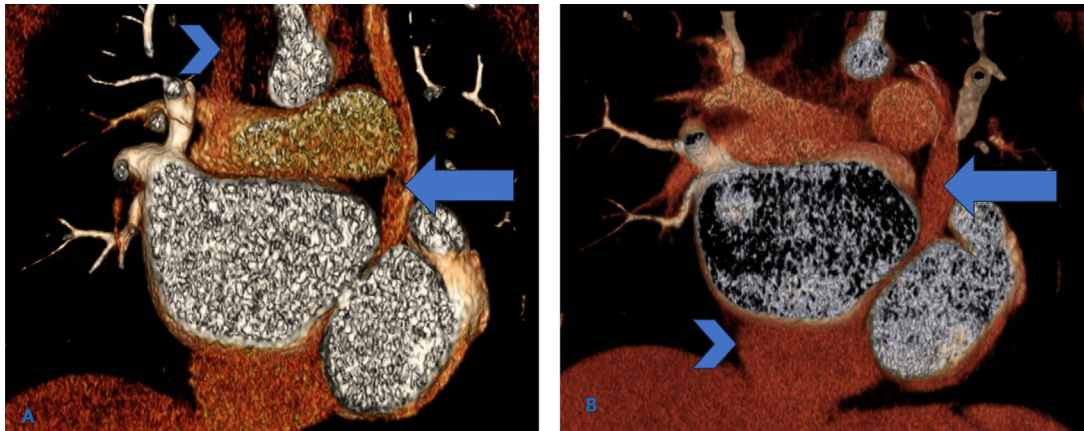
(A) 3D reconstruction cardiac CT scan shows double SVC, persistent left-sided SVC (arrow), and normal right-sided SVC (arrowhead). (B) 3D reconstruction cardiac CT scan shows persistent left-sided SVC (arrow) draining through the coronary sinus into the right atrium (arrowhead).
